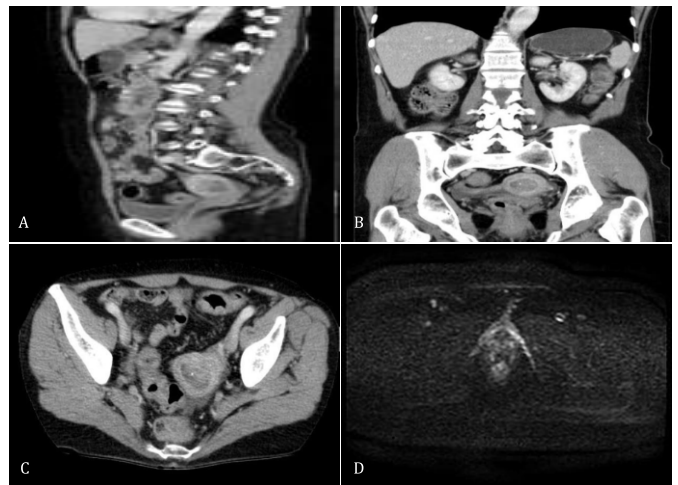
(b): MRI Images of endometrial carcinoma (A) Sagittal section of MRI showing Endometrial Carcinoma (B) Coronal sectional of MRI showing Endometrial Carcinoma (C) Axial section of MRI showing Endometrial Carcinoma (D) DWI Axial section showing endometrial carcinoma.
